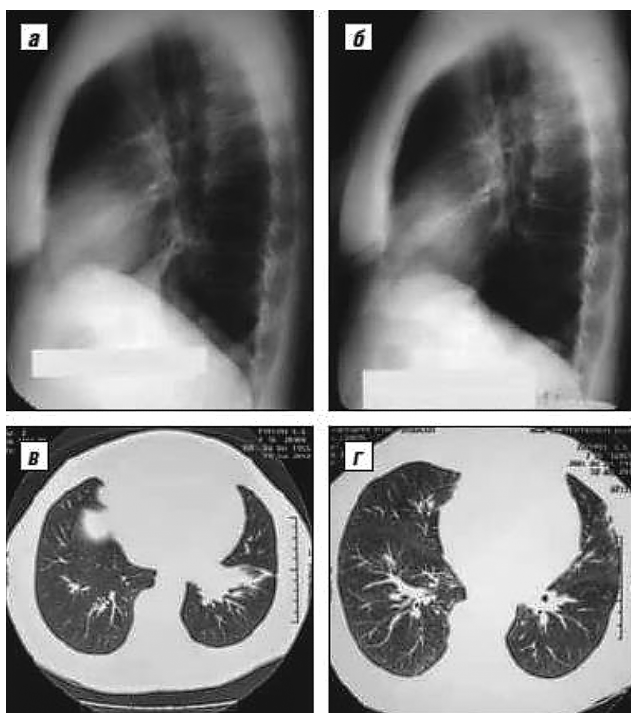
A* — X-ray exam (lateral view) prior to bronchoscopy; *B* — X-ray exam after therapeutic bronchoscopy procedures; *C* — Chest CT scan before treatment; *D* — Chest CT scan after therapeutic bronchoscopy procedures
